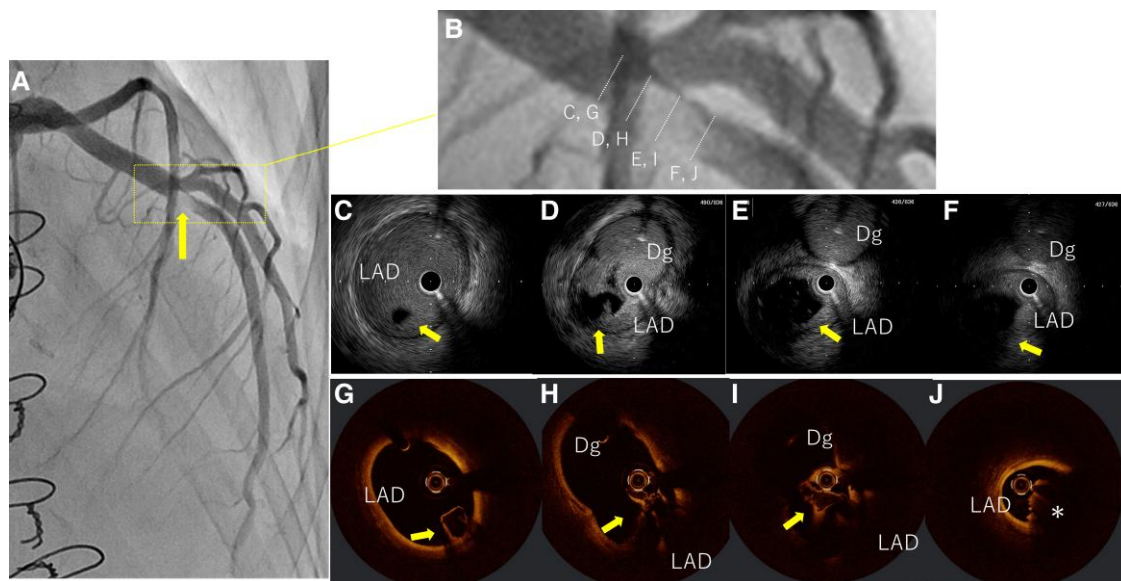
(A and B) Coronary angiography (CAG) demonstrated filling defect in the mid-LAD artery (arrow). (C–F) Intravascular ultrasound images showed a mass with clear margins, almost no echogenicity on the inside. (G–J) Optical coherence tomography images revealed a crystal-like structure with no internal signal, and a red thrombus (asterisk) attached to the distal side. LAD, left anterior descending; Dg, diagonal branch.
